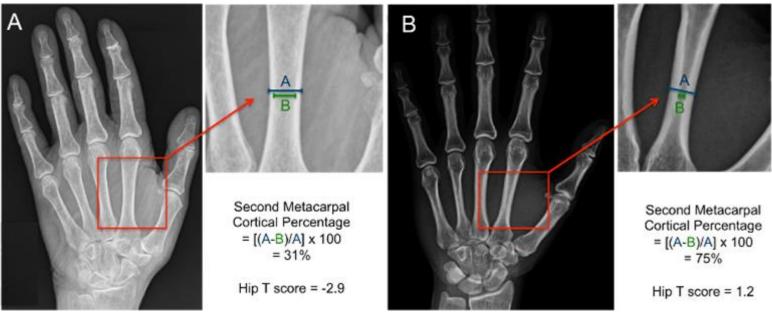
Hand X-ray (A shows signs of osteoporosis while B is normal) [41]
